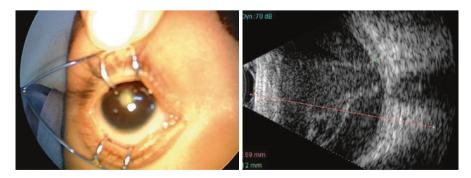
Partially resolved endophthalmitis with systemic antibiotics noted few days after an acute systemic septic episode. This child presented with leucocoria and a shrunken globe resembling a pseudoglioma (*left*). The child was referred as a case of retinoblastoma. The ultrasonography shows no mass but showed a degenerated retinal detachment with low-intensity echoes in vitreous and subretinally—a prephthisical stage (*right*)
